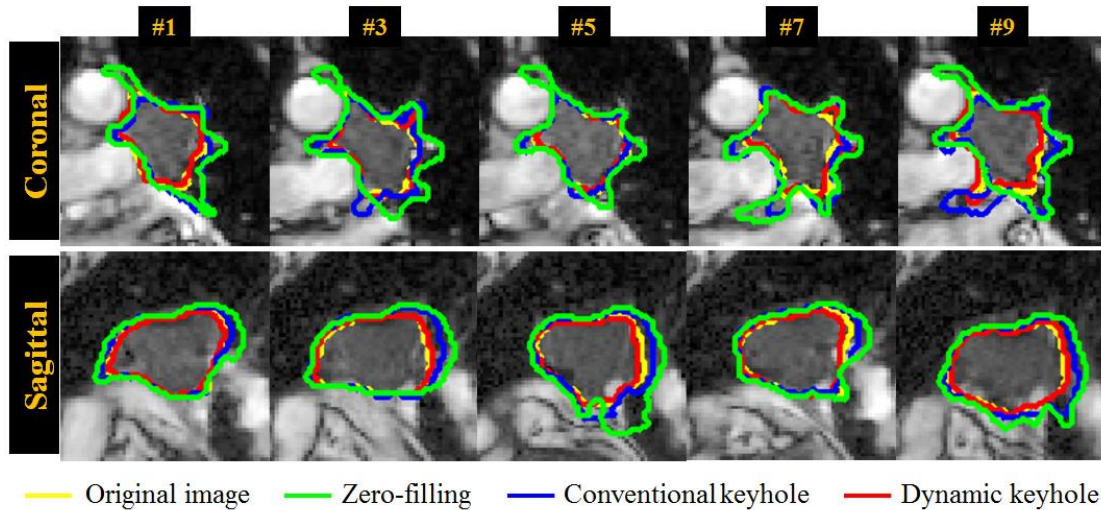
Tumor areas contoured on the original and reconstructed images using constant keyhole size: original image (yellow), zero-filling (green), conventional keyhole (blue) and dynamic keyhole (red). Image number (#) indicates the sequential order of MR images.
